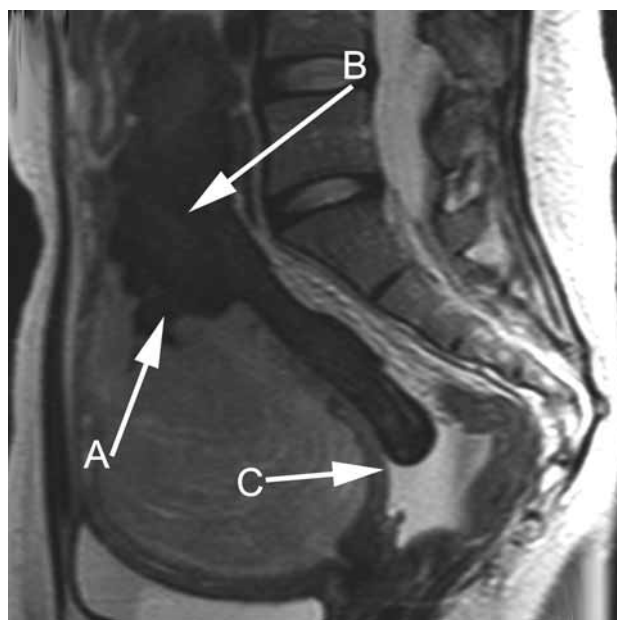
T2 weighted magnetic resonance imaging depicted a markedly distended uterus filled with blood. Arrow A indicates the site of uterine wall rupture in the fundal area. Arrow B indicates blood clots extravasating into the abdominal cavity, and arrow C indicates the markedly thinned myometrium.
